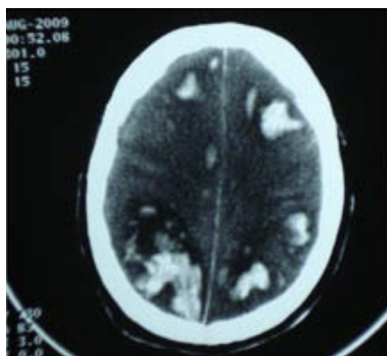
Cranial CT scan showing multifocal hemorrhage in frontal, parietal, temporal and occipital lobes, as well as SAH and intraventricular hemorrhage
